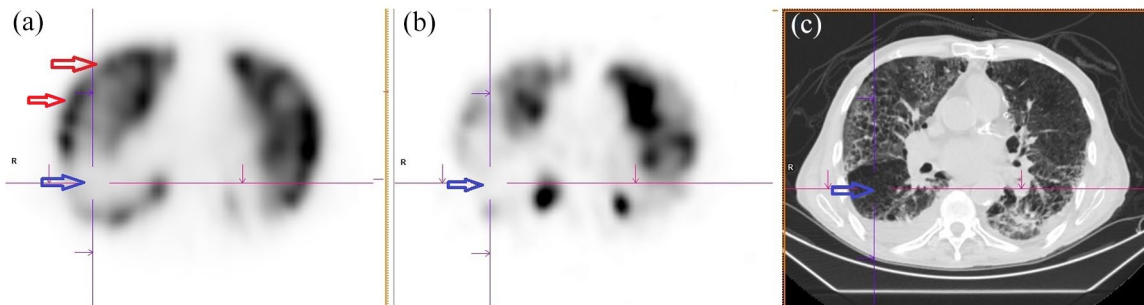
Patient no. 2. Perfusion (a), ventilation (b), and CT scan (c). Blue arrow: non-COVID-19-involved area of the right Fowler lobe, with paradoxically matched hypoperfusion and hypoventilation, while the COVID-19-involved area of the right superior lobe just in front remains perfused with a slightly hyperperfused peripheral halo (red arrow).
